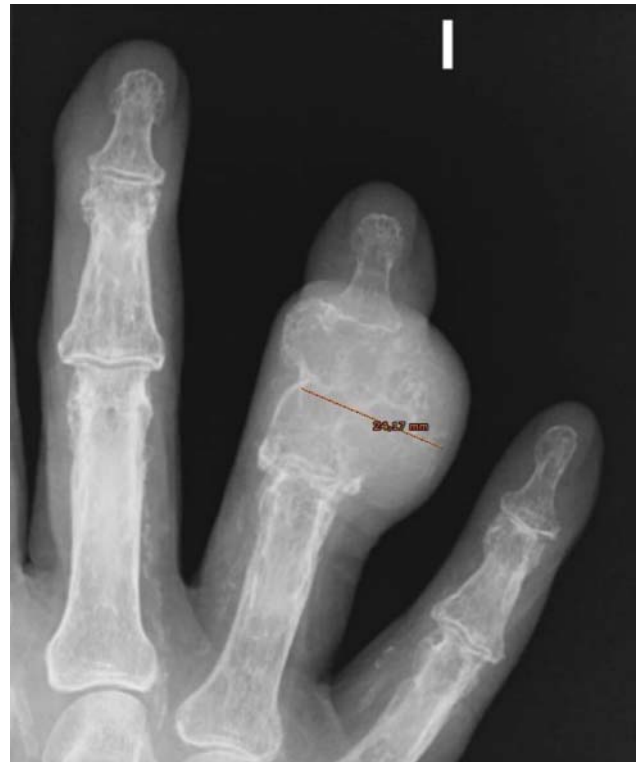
Posteroanterior simple radiography revealing an expansive lesion at the middle phalanx of the fourth finger, with different size and shape but at the same location seen 2 years ago.
